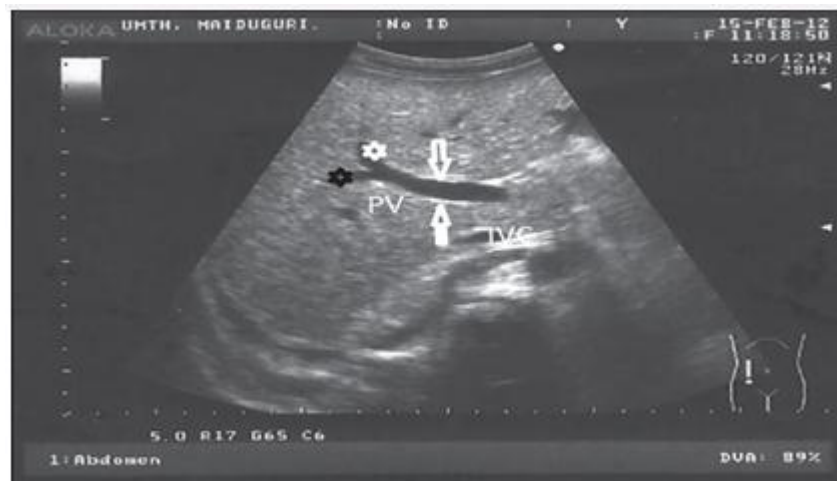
Shows normal portal vein ultrasound (au/members2003)
